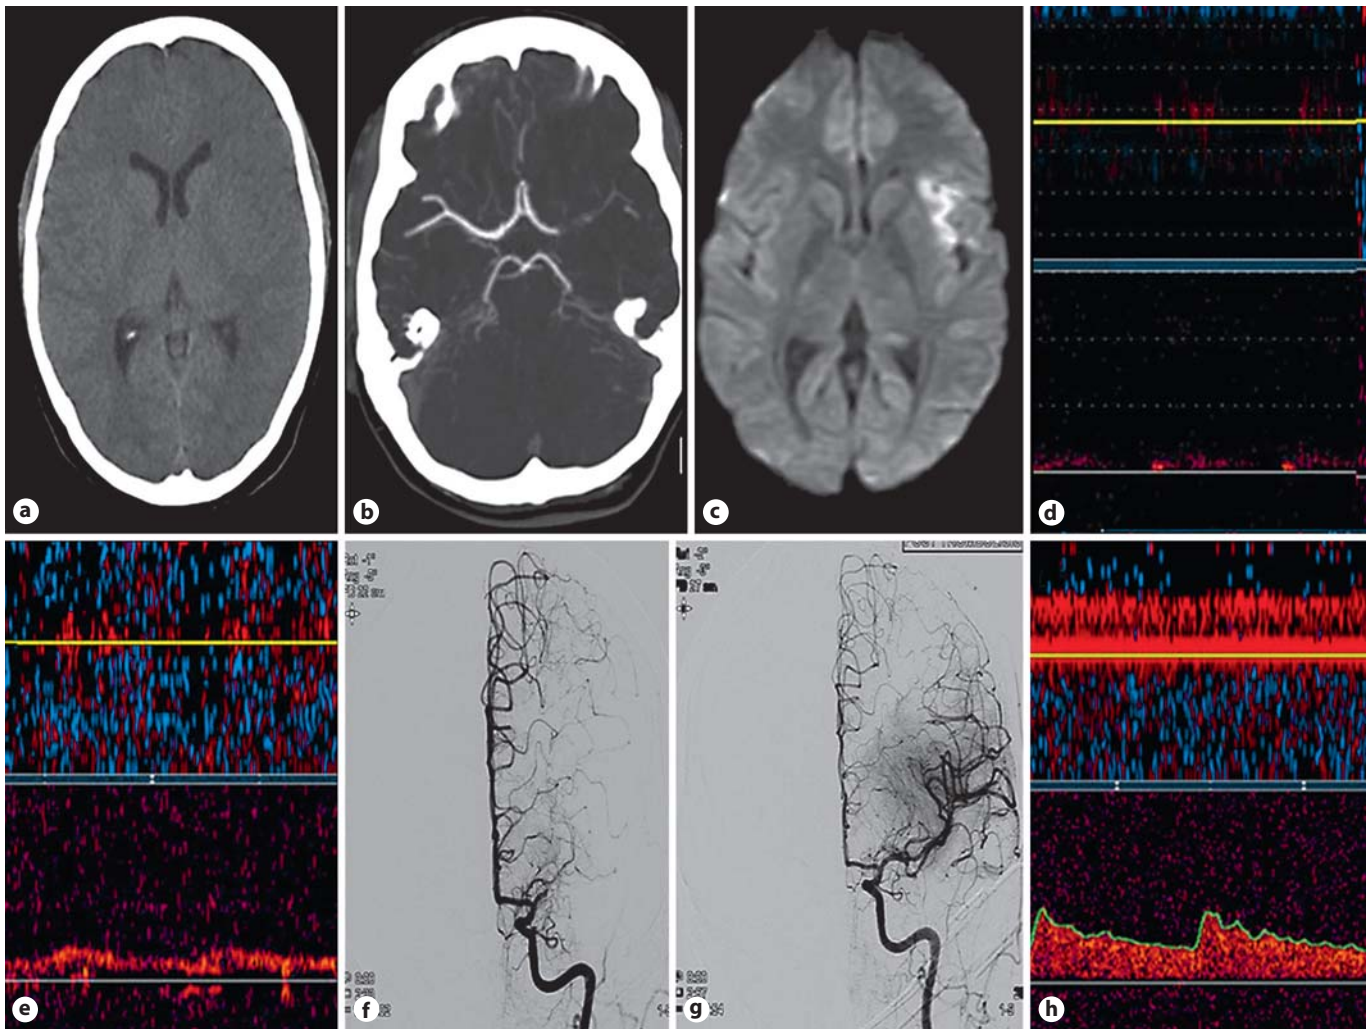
Case 11, an 18-year-old white female, arrived within 93 min of symptom onset of a left MCA stroke. Initial NIHSS score of 9 points. a Brain CT scan demonstrating no abnormalities. b CTA showing M1 MCA occlusion. c DWI showing small insular ischemic changes. d TCD at the beginning of thrombolysis with signal showing occlusion of M1 MCA TIBI-1. e TCD at the end of intravenous thrombolysis. The patient had improved by 2 points on the NIHSS scale, but there was minimal improvement on M1 MCA
